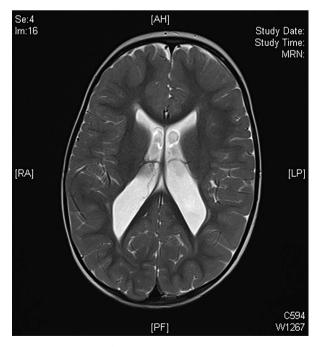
MR scan of brain (T2-weighted) showing periventricular leukomalacia associated with preterm (24–32 weeks gestation) injury to the brain.
